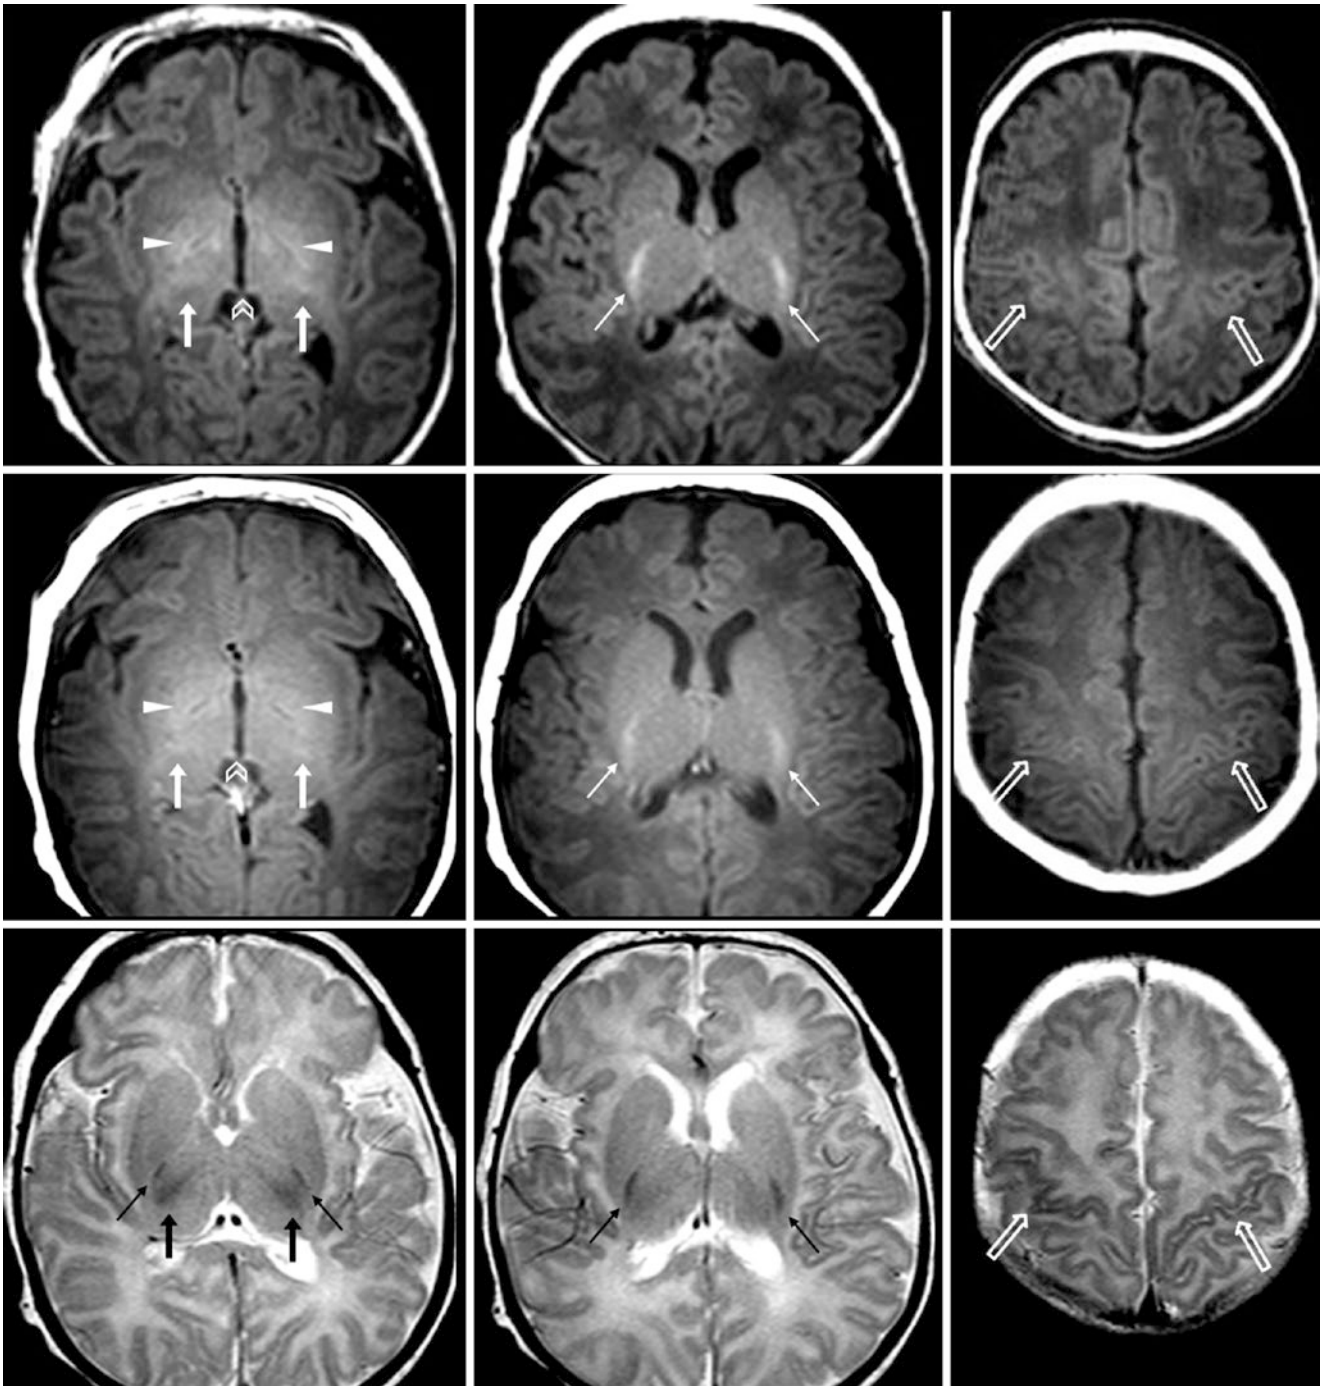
A 21-day-old term neonate with poor feeding and a normal 3T MRI. *Top row:* Spoiled GE T1WI shows only mildly bright signal within the posterior putamina (*arrowheads*) and VLT (*arrows*). *Middle row:* SE T1WI shows even less bright GP and VLT, compared with GE T1WI. Note a mildly bright habenular commissure (*chevrons*). *Bottom*
